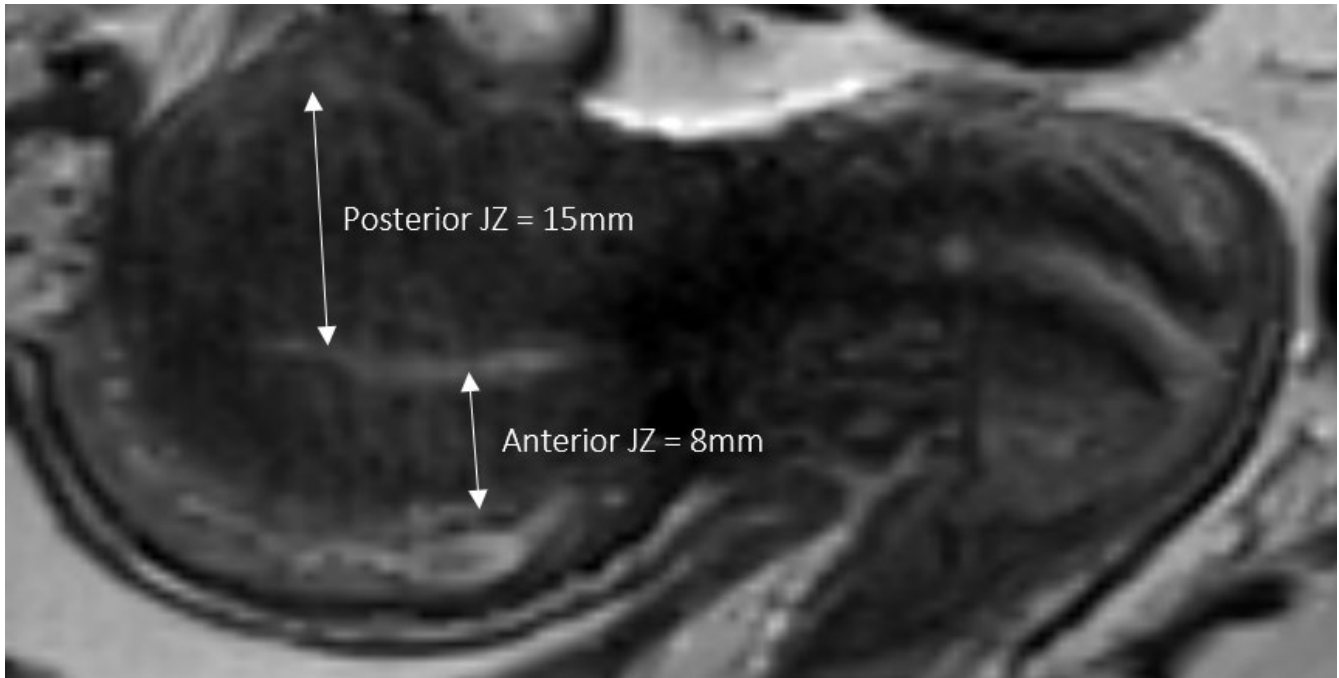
Sagittal T2 W MRI showing junctional zone (JZ) and myometrial (M) thickness. The JZ to myometrium ratio here is 0.8 (80%)
